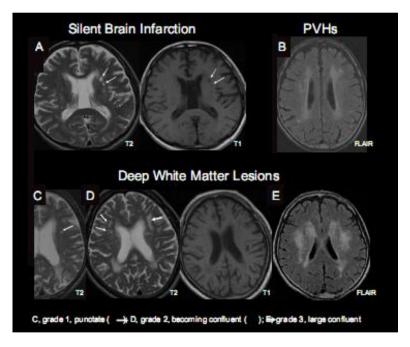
MRI of silent brain infarction (A), periventricular hyperintensities (PVHs)(B), and deep white matter lesions (C, D, and E). The combination of T1WI, T2WI, and FLAIR images is required to accurately detect both silent brain infarction and mild WMLs. Therefore, T1-weighted (TR/TE = 510/12 msec), T2-weighted (TR/TE = 4,300/110 msec), and FLAIR (TR/TI/TE = 6,750/1,600/22 msec) images were obtained with a slice thickness of 6 mm with a 1 mm interslice gap with a brain MRI (1.0T, Shimadzu, Magnex XP, Kyoto, Japan). Brain infarcts were shown as low signal intensities on T1-weighted images, and their size was 5 mm or larger. The WMLs were defined as isointense with normal brain parenchyma on T1-weighted images, and high signal intensity areas on T2-weighted images. We used the validated rating scale of DWMLs by Fazekas et al: Grade 0, absent; Grade 1, punctate foci; Grade 2, beginning confluence of foci; Grade 3, large confluent areas [28]. For PVHs, we determined the presence and severity (Grade 0, absent; Grade 1, pencil thin; Grade 2, smooth halo lining) using FLAIR images.
